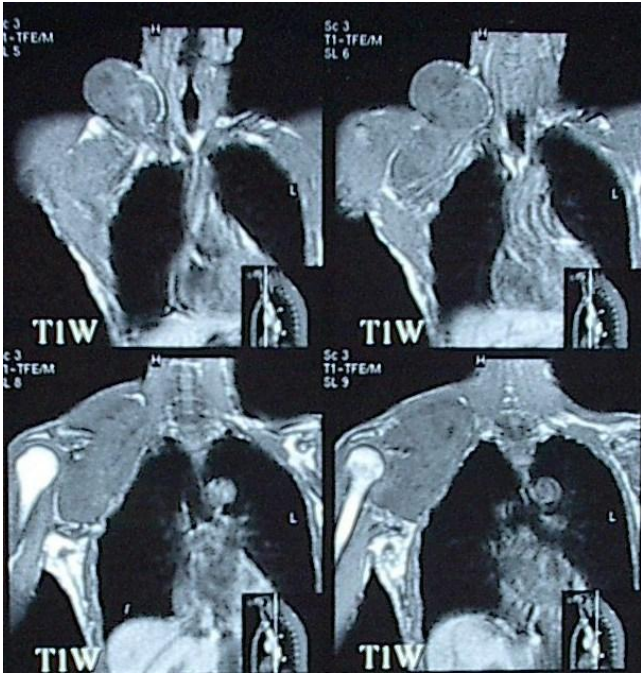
MRI of First Patient without Contrast
